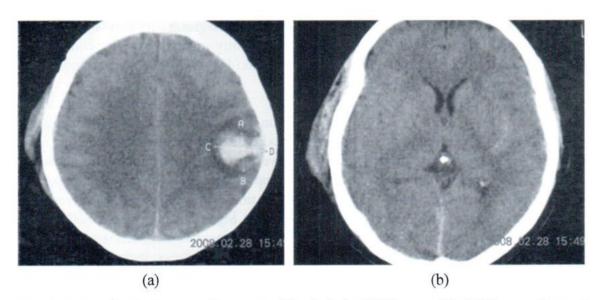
CT scans of a 41-year-old woman with admission GCS score=10. Axial non- enhanced CT revealed an intracerebral hematoma of cortical left frontoparietal lobe (a). Associated minimal subarachnoid hemorrhage was also detected as increase attenuation of sylvian fissures (b).
